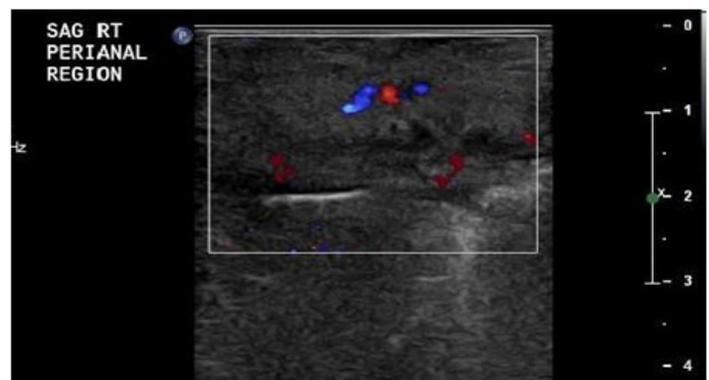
Ultrasound image acquired from the right perianal region demonstrating linear echogenicity consistent with foreign body, soft tissue edema and increased vascularity
